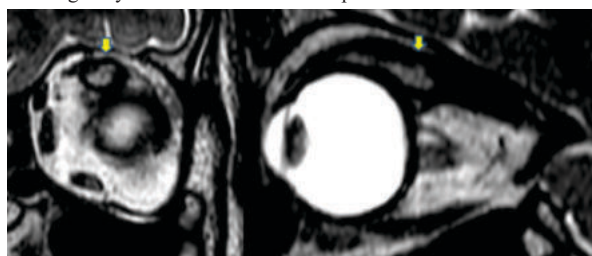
T2 weighted MRI after 4 weeks of treatment showing reduced size (~6x4x8mm) and signal intensity of the lesion in the left superior rectus muscle.
